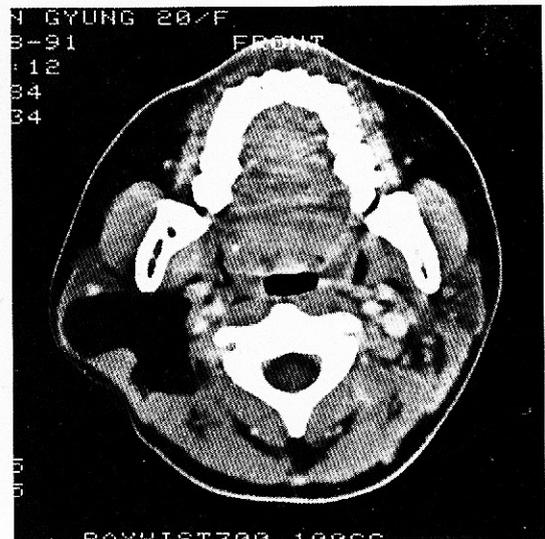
CT scan of the parotid mass reveals a well demarcated low density mass in the parotid gland which contains linear and mottled densities.
